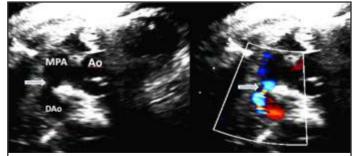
Fetal echocardiography showing short axis view at the level of great vessels. Premature restriction of PDA (arrow) is seen between descending aorta and MPA.
